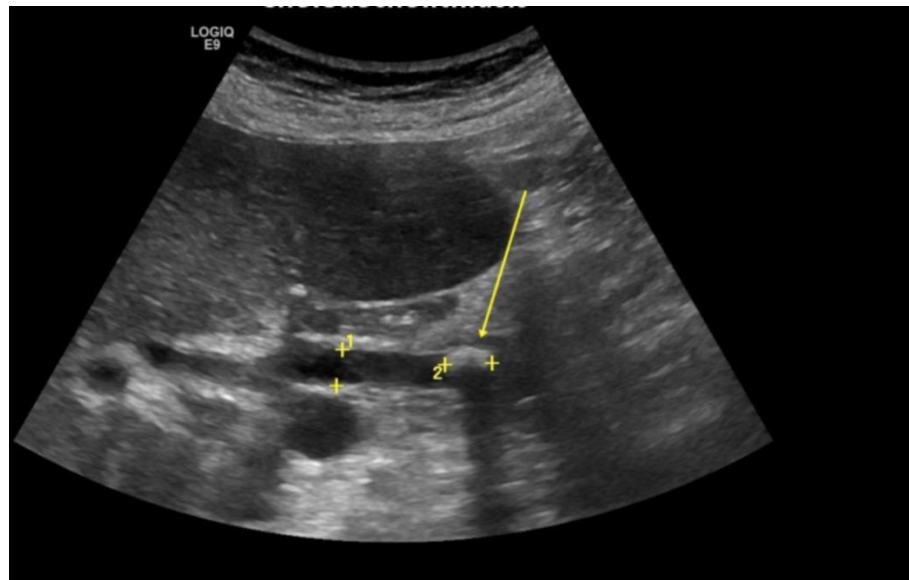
Ultrasound examination: dilatation of the common bile duct (arrows indicate the enlarged choledochus) due to a stone in the distal section. A hyperechogenic inclusion with acoustic shadowing (indicated by an arrow with an asterisk) is noted, characteristic of a concretion in the common duct.*
